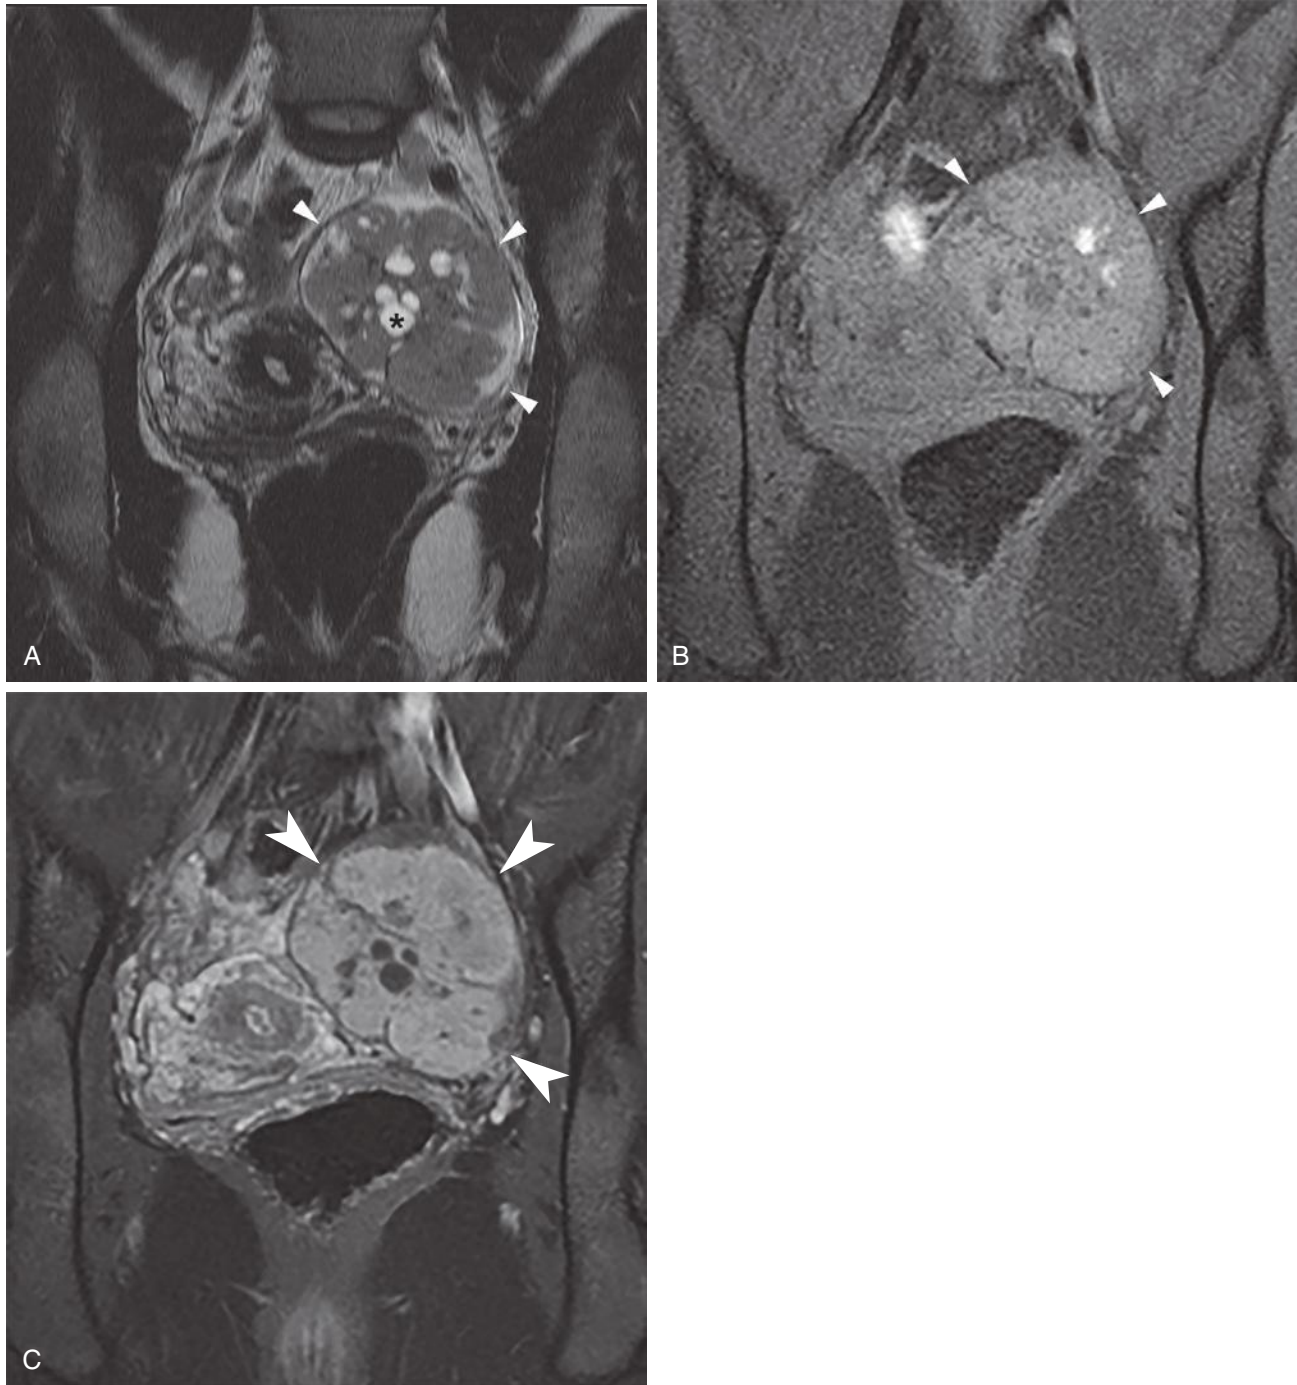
Granulosa cell tumor of the ovary. Coronal T2-weighted (A), fat-saturated T1-weighted (B), and gadolinium-enhanced fat-saturated T1-weighted (C) images show a heterogeneous predominantly solid left ovarian mass (*arrowheads*) with multilocular cystic spaces and enhancement of the solid component (C). Several of the small cystic spaces are hyperintense on T1-weighted image (B), suggesting that they contain proteinaceous material or blood products.
